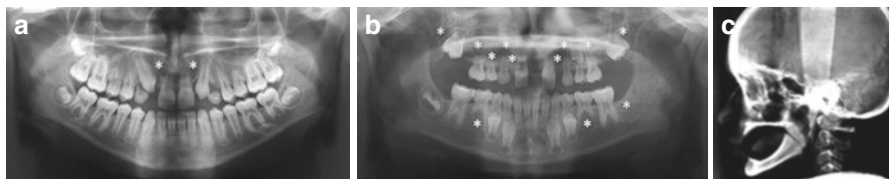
Terminology of tooth agenesis. (a) Hypodontia 1–5 teeth absent (third molars excluded). Dental panoramic tomograph shows the absence of upper permanent lateral incisors (*asterisks*). (b) Oligodontia—six or more teeth absent (third molars excluded). Dental panoramic tomograph shows the absence of 12 permanent teeth (*asterisks*). (c) Anodontia—absence of all teeth (primary and/or permanent dentitions). Lateral skull radiograph shows a complete absence of teeth
